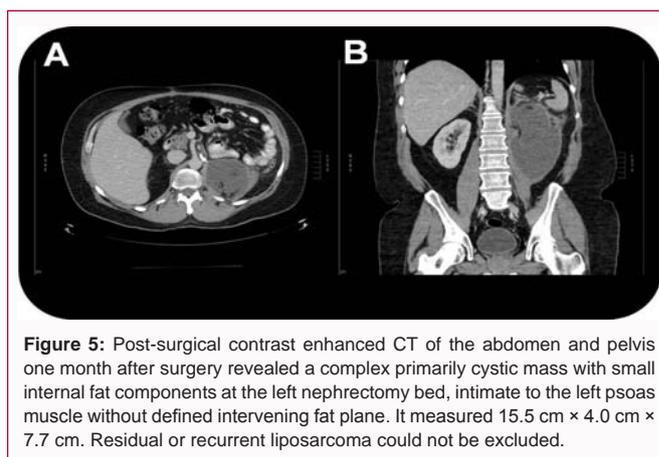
Post-surgical contrast enhanced CT of the abdomen and pelvis one month after surgery revealed a complex primarily cystic mass with small internal fat components at the left nephrectomy bed, intimate to the left psoas muscle without defined intervening fat plane. It measured 15.5 cm × 4.0 cm × 7.7 cm. Residual or recurrent liposarcoma could not be excluded.
